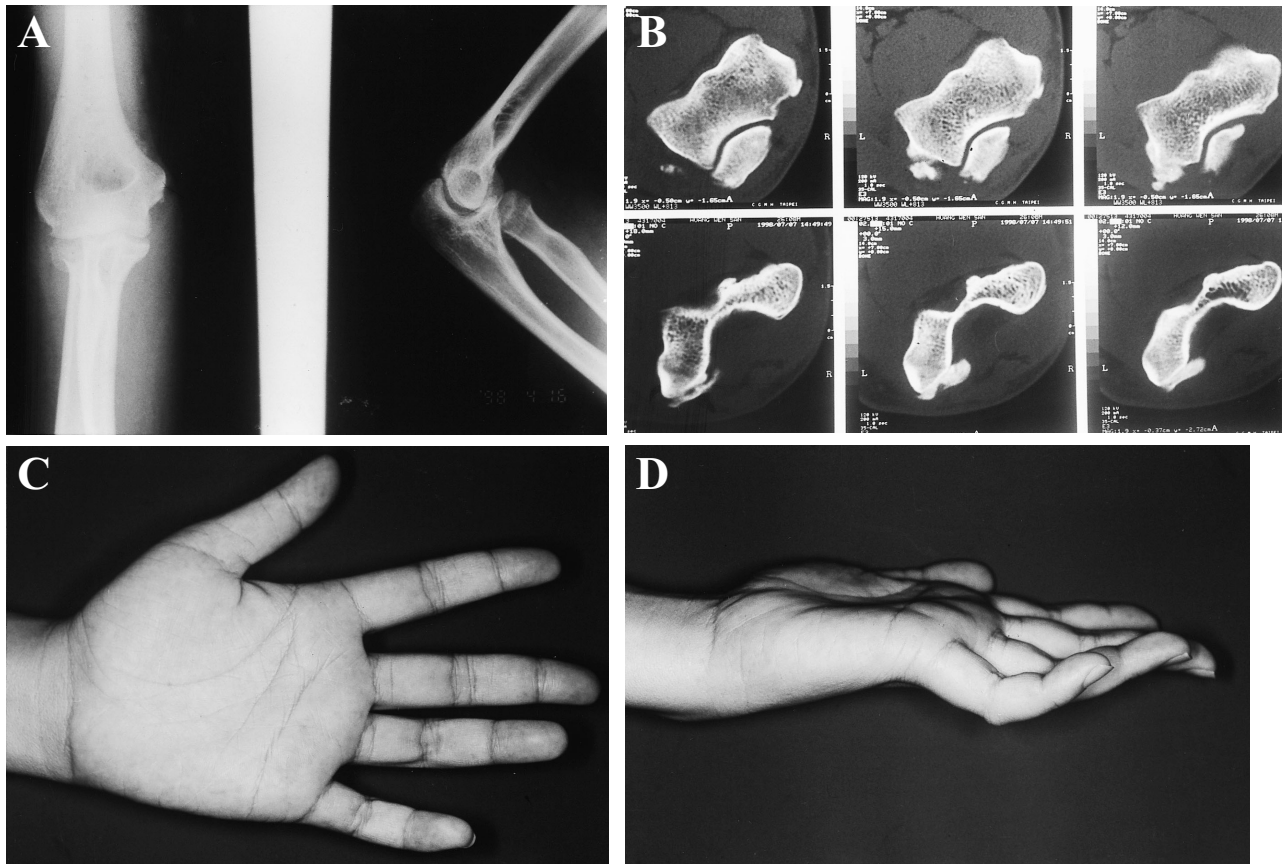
(A) Radiograph showing heterotopic ossification over the medial and lateral sides in a patient (no. 6) with limited elbow motion. (B) CT revealing heterotopic ossification over the cubital tunnel. (C) Ulnar nerve palsy with adductor insufficiency. (D) Ulnar nerve palsy with claw digit deformity.
